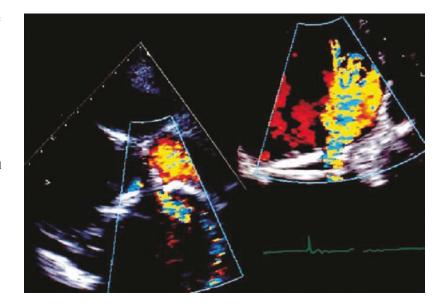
Paraprosthetic mitral regurgitation. Although the interatrial portion of the jet is incompletely seen on transthoracic imaging (a) because of shielding, the neck and interventricular flow acceleration are usually visible. The interatrial jet is more easily imaged on TEE (b)
